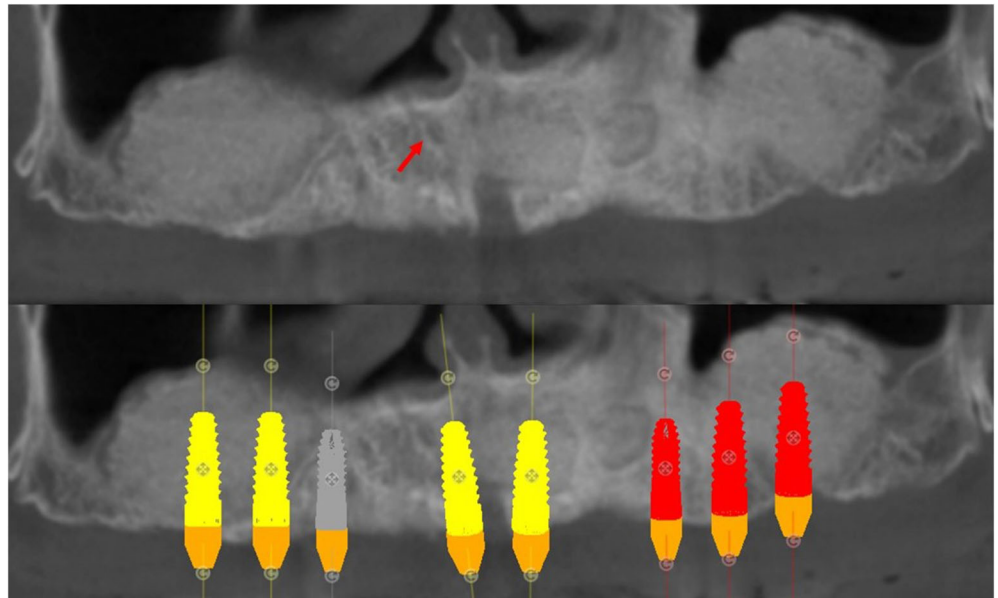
CBCT coronal sections showing the accessory foramen of a Canalis Sinuosus (CS) issuing into the palatine mucosa (see red arrows)
